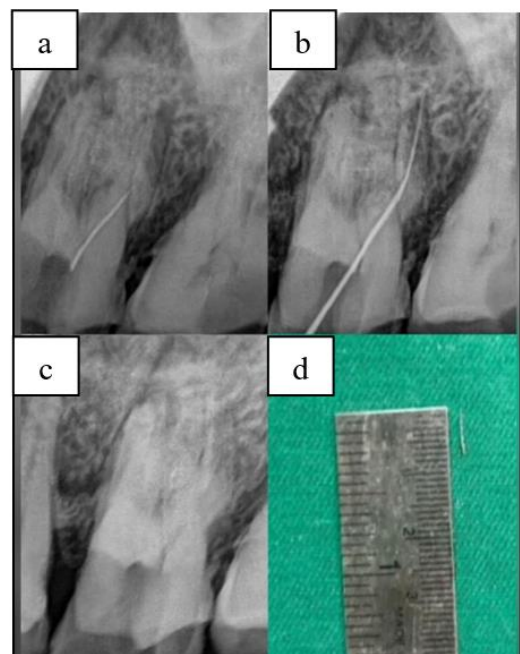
Sequence of instrument removal in case 2. (a): Intraoral periapical showing separated instrument in disto buccal root of maxillary 1st molar. (b): Intraoral periapical showing separated instrument removal from the canal. (c): Intraoral periapical showing a clear distobuccal canal (d): Retrieved instrument
